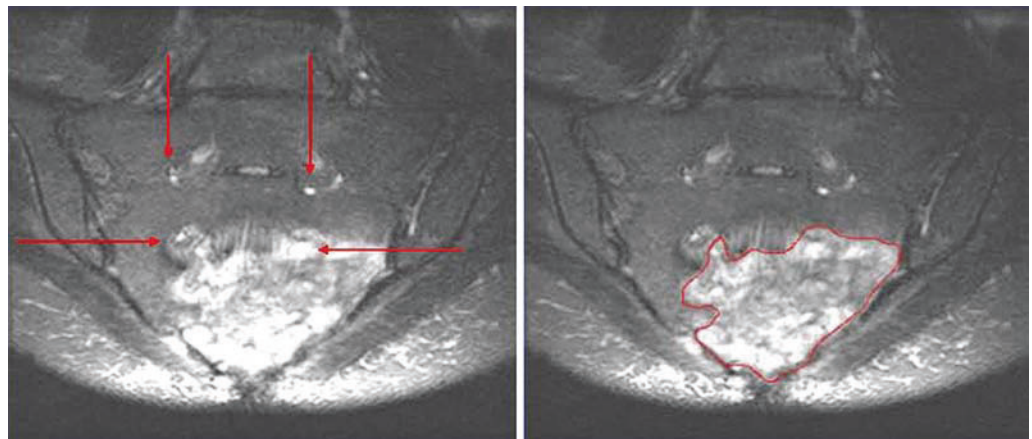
CT scans in a patient with recurrent rectal cancer showing recurrent sacral nerve involvement (*left, arrows*) and recurrent tumor (*right, line*).
